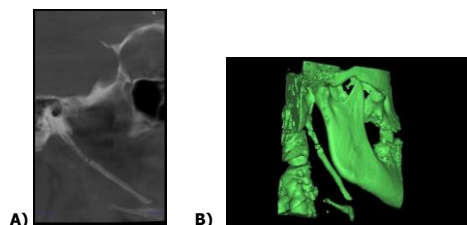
A. Sagittal CBCT image shows elongated styloid process at right side.
